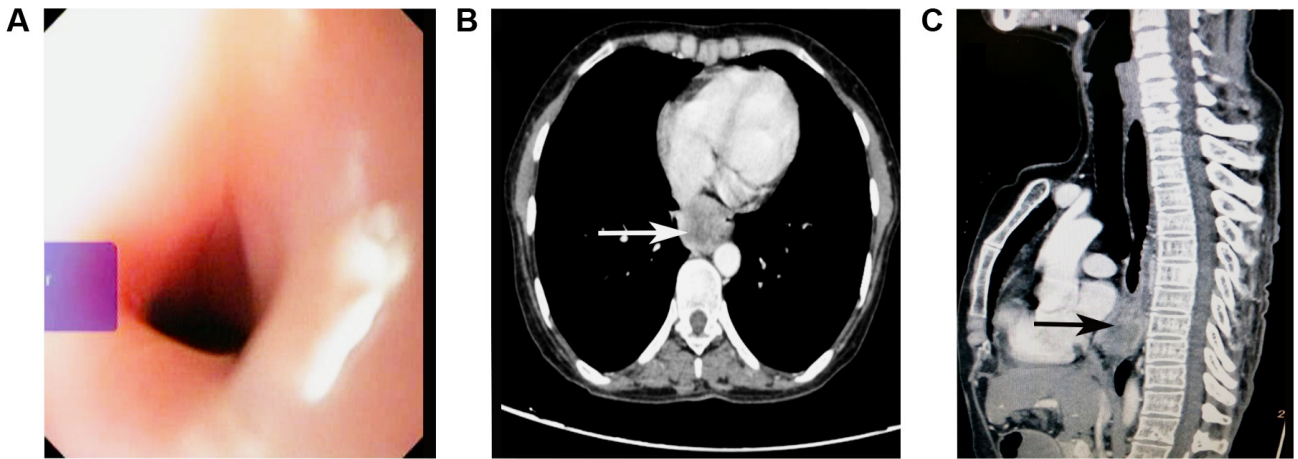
Upper gastrointestinal endoscopy reveals a smooth stricture with normal overlying mucosa in the lower esophagus starting at 28 cm from central incisor (A). A heterogeneously enhancing soft tissue lesion of size approximately 3.2 cm × 2.5 cm involving the distal thoracic esophagus with near complete lumen occlusion can be seen on the cross-section (white arrow in B) and sagittal section (black arrow in C) contrast-enhanced computed tomography images.
